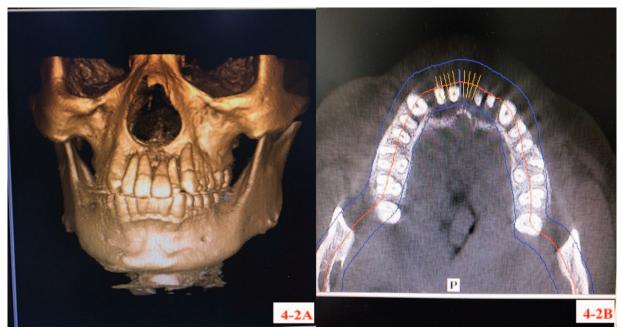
CT images. A and B, Exposure of the upper anterior dental roots due to destruction of the maxillary alveolar bone.
